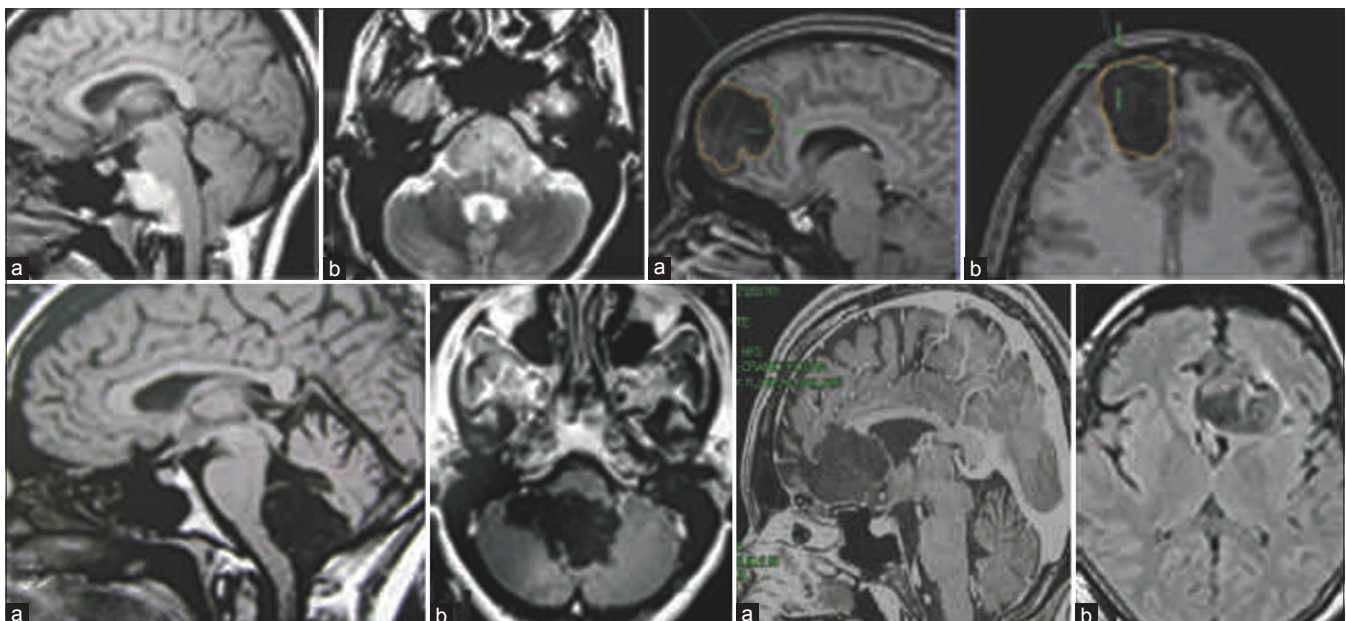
T1-weighted MRI scans with contrast enhancement in cases of IDETs found in this series. a (sagittal) and b (axial).
